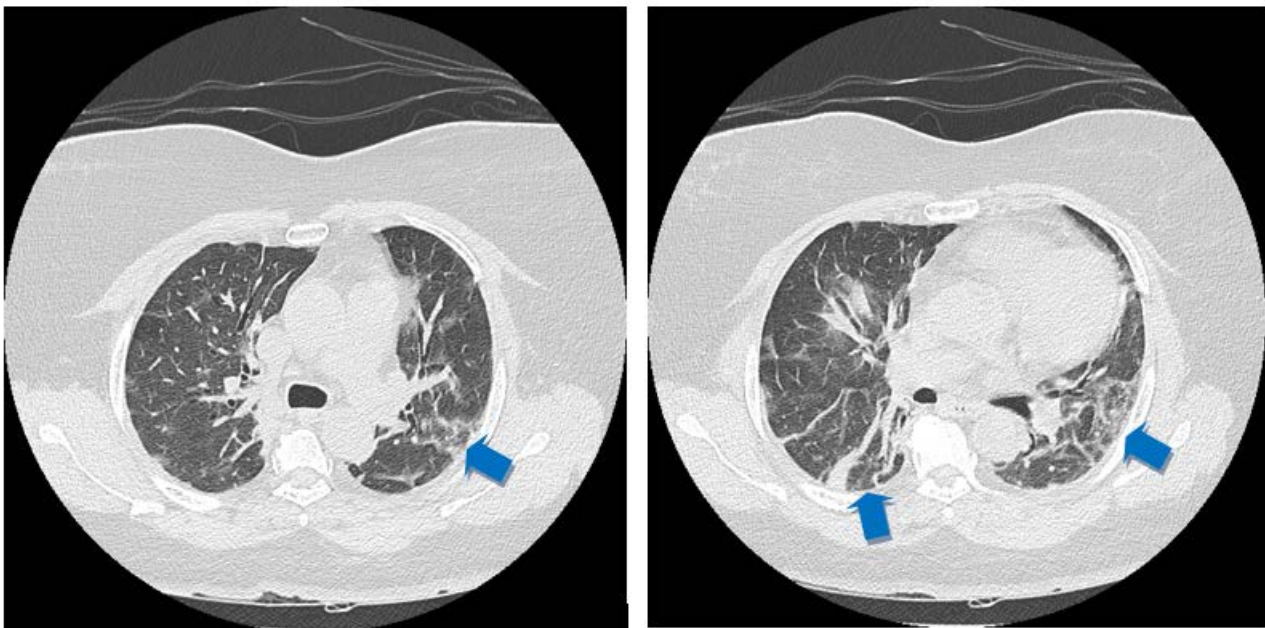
Chest CT (June 3, 2021): bilateral lung disease; ground-glass opacities and fibrous parenchymal bands (arrows).
